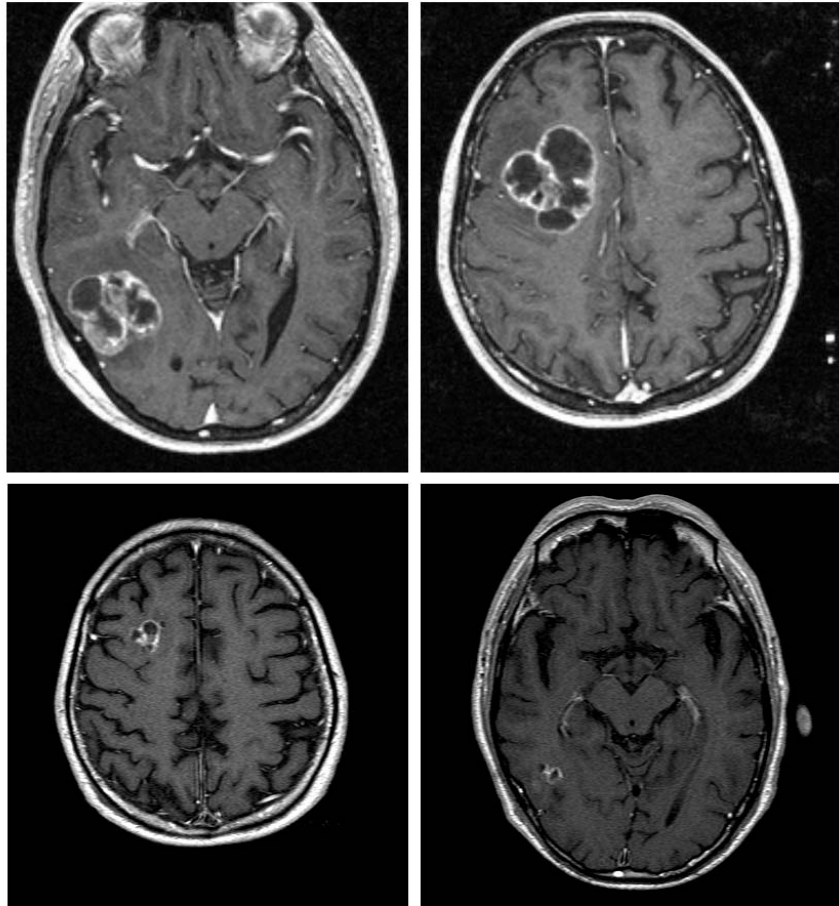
Left:* Magnetic resonance image revealing large right frontal and posterior temporal metastases from carcinoma of the esophagus before treatment. *Right:* Excellent volume shrinkage of both metastases is seen 3 months after GKS.
